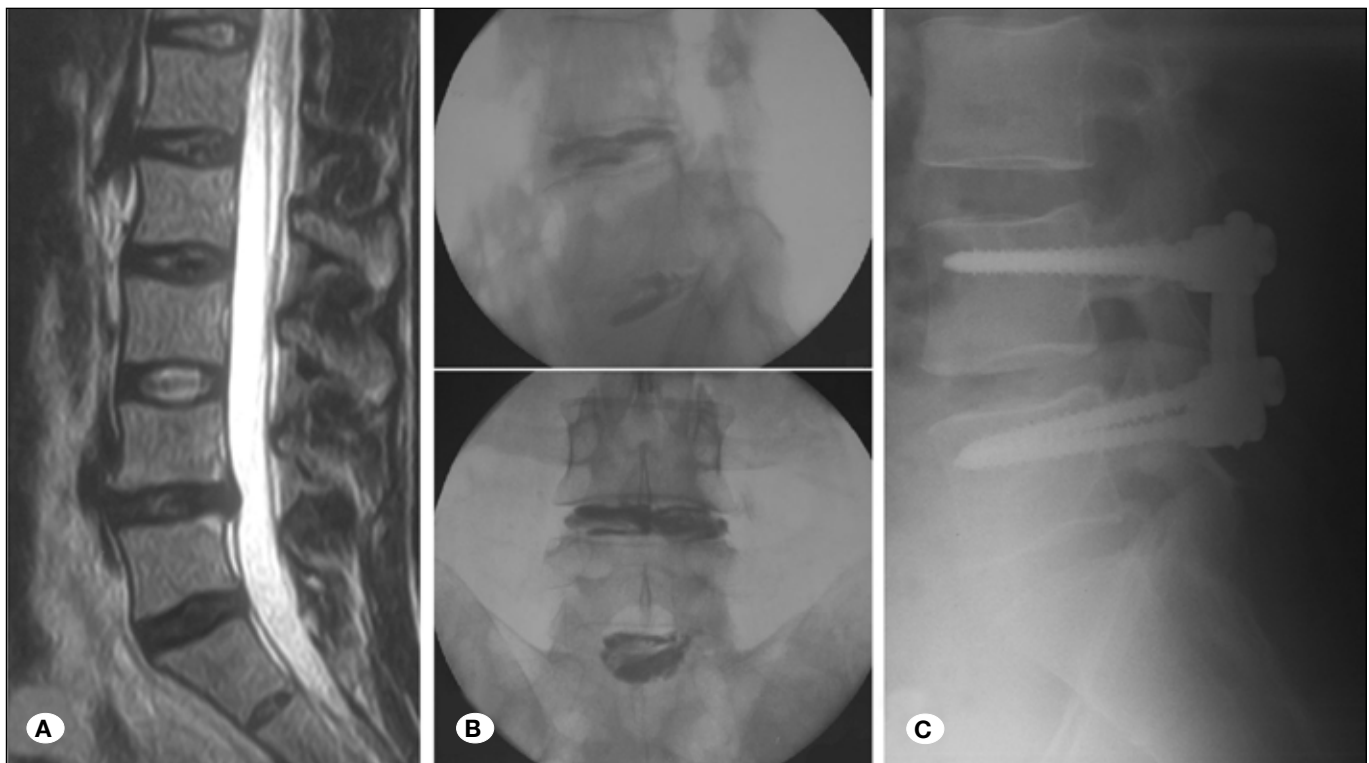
A) Sagittal T2 lumbar MRI showed L4-5 and L5-S1 degenerative disc disease B) Discography showed normal findings at L5-S1 level. There was a leakage at the L4-5 level. C) Therefore only the L4-5 level was stabilized with dynamic instrumentation.
